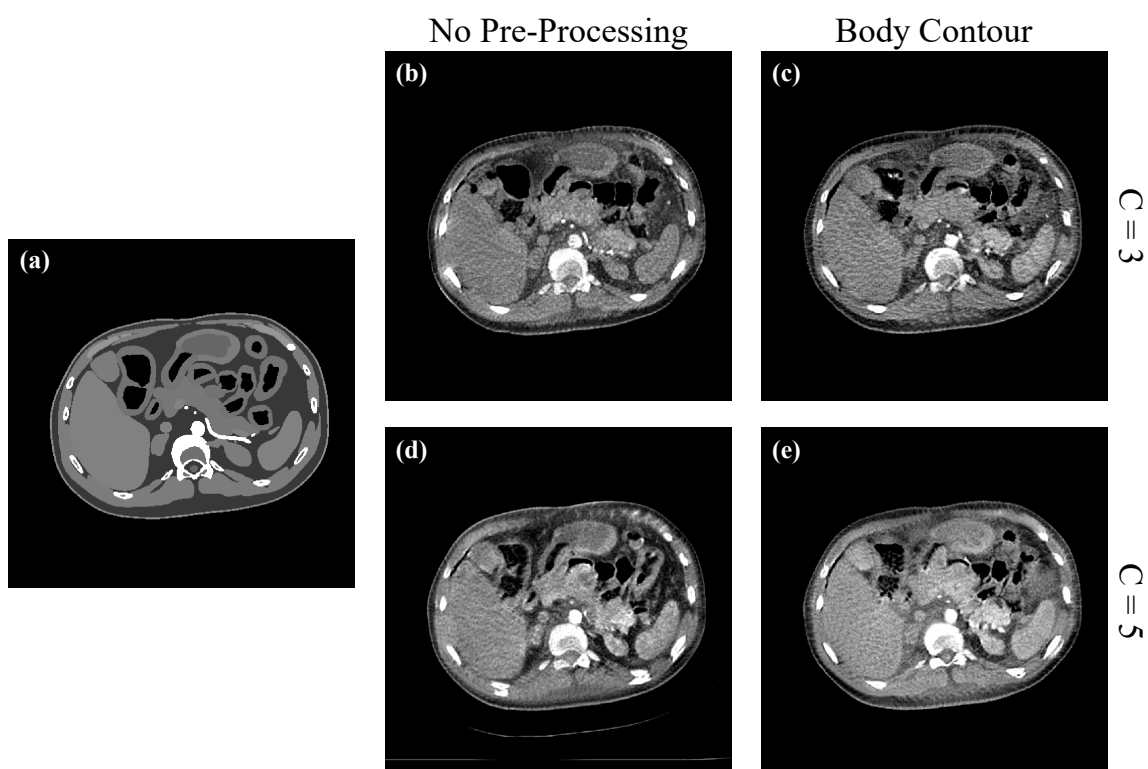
(b), (c), (d) and (e) axial slices of the synthetic CT images generated with the Res-Nets trained in the configuration study ($C \hat{=}$ number of input slices) and (a) the corresponding XCAT slice. Reprinted by permission from Springer Nature Customer Service Centre GmbH: Springer Nature International Journal of Computer Assisted Radiology and Surgery ©2019.
